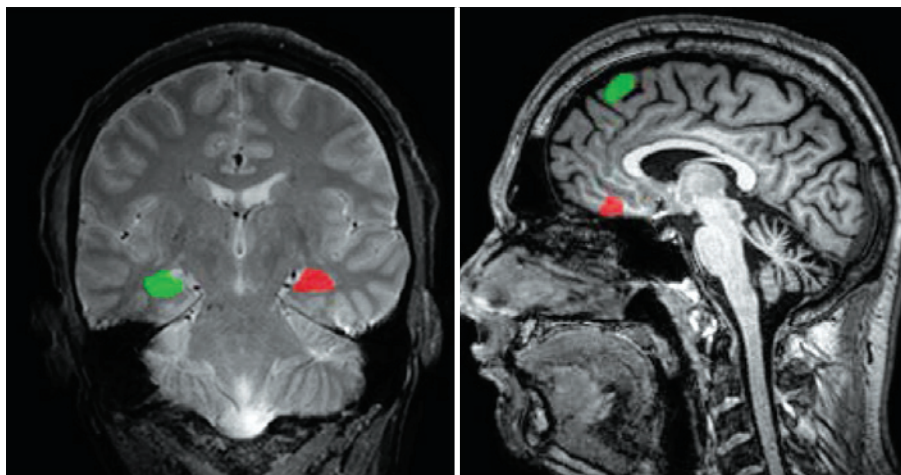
Left: T2 coronal MRI image presenting the regions of interest for analysis of the hippocampi. Right: T1 sagittal MRI image presenting the ROIs for the analysis of cortical portions.
